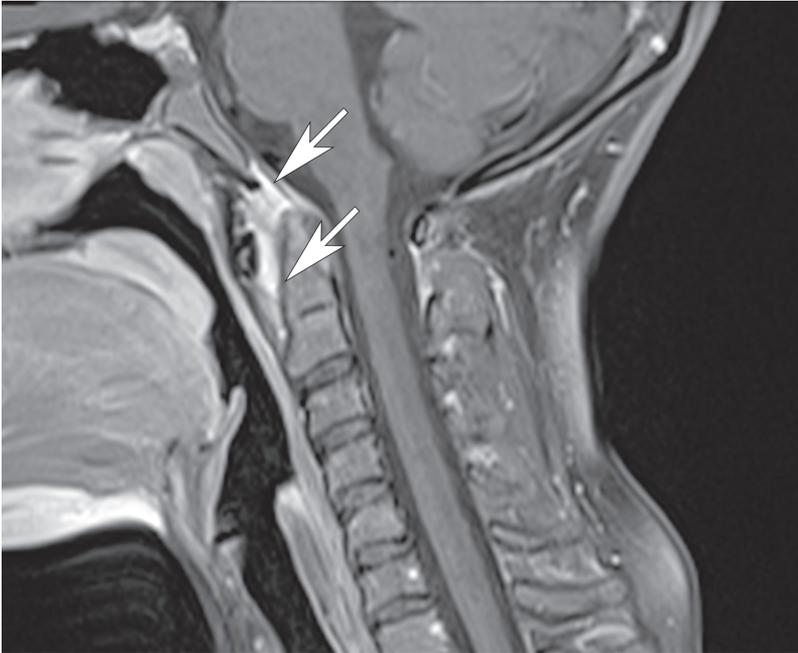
A contrast-enhanced cervical spine magnetic resonance image demonstrated increased separation of the anterior arch of C1 from the dens, measuring 5 mm, with enhancing soft tissue between the tectorial membrane, anterior arch of C1, and around the dens, in keeping with enhancing synovium (arrows).
